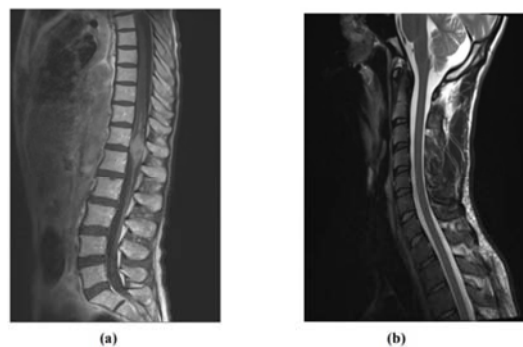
Input of a sample MRI image (a) is tumor affected patient and (b) is normal patient.
